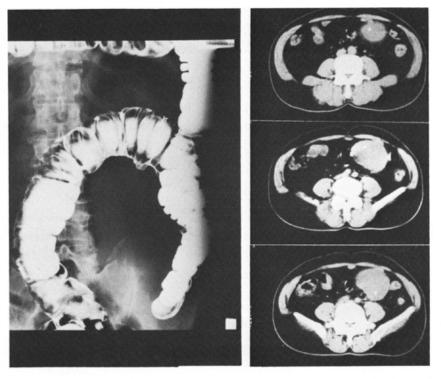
Photograph of barium enema (left) showing displacement of the sigmoid colon and computed tomographs (right) demonstrating a homogeneous mass in the abdominal cavity.
